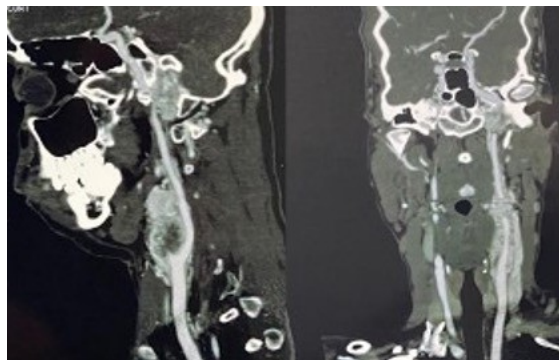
CT and CTA of brain and neck showing left-sided glomus jugulare associated with carotid body tumour. Source: Figure by authors.
